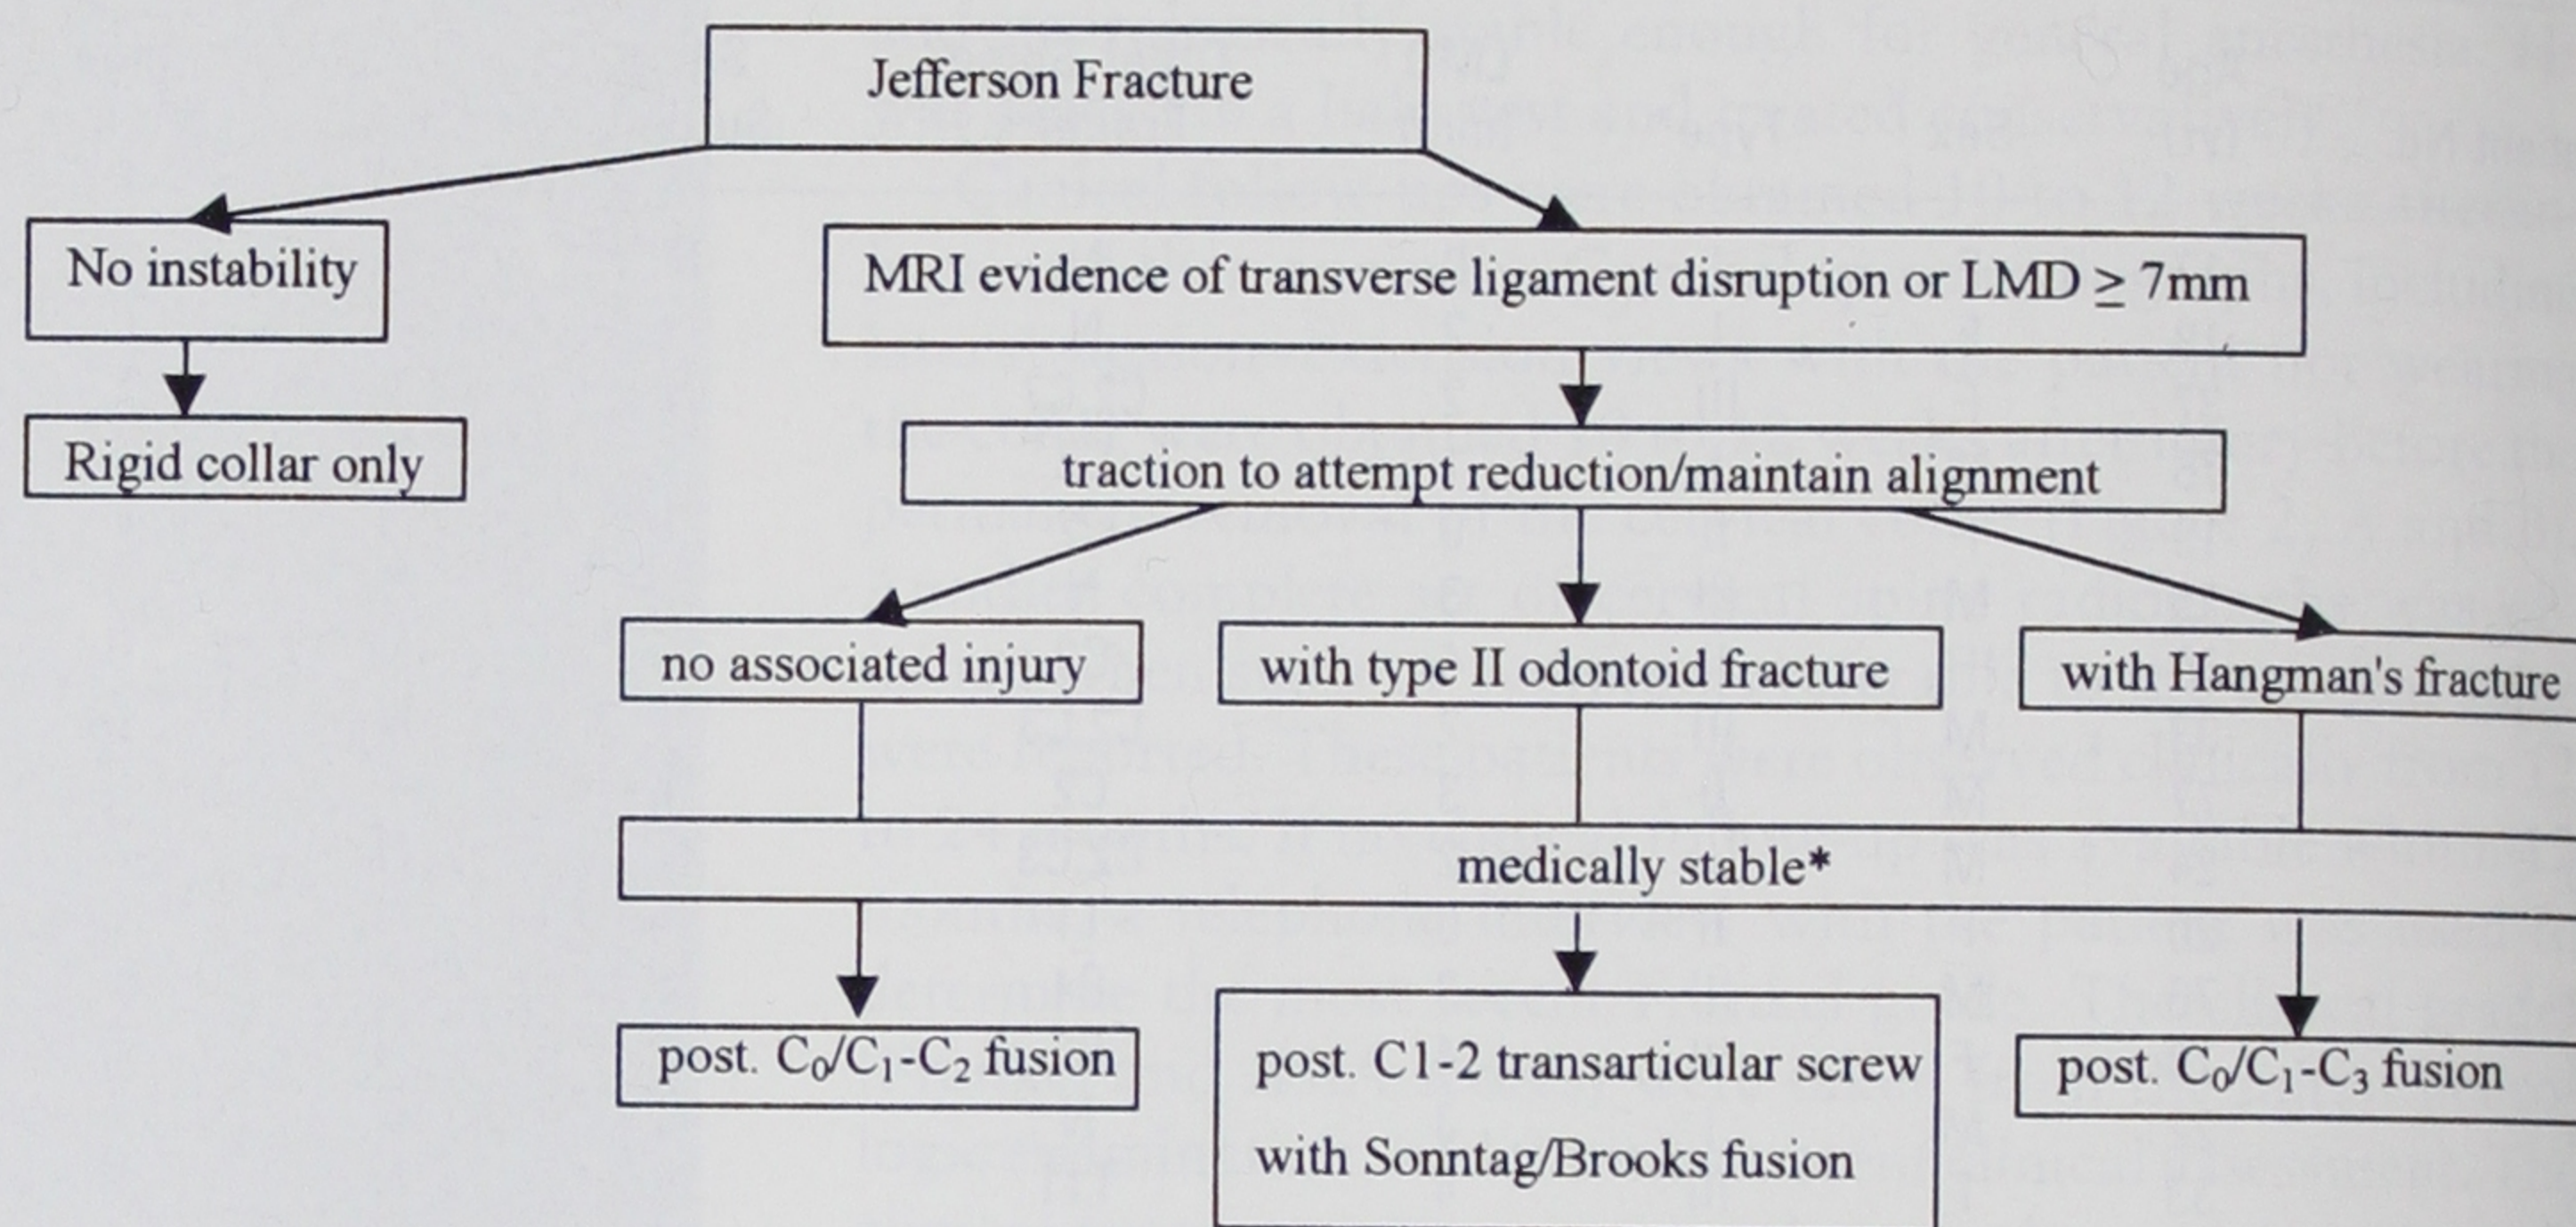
Proposed treatment algorithm for Jefferson fracture with or without associated axis fracture after evaluation with plain radiograph series, computed tomographic scan, and if necessary, magnetic resonance imaging.
